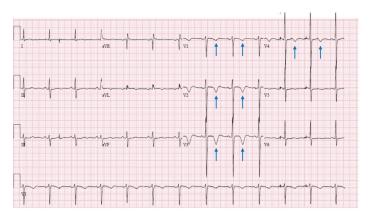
Initial echocardiogram with deep and symmetric T-wave inversions in leads V1-V4 (blue arrows), with no Q-waves, normal R-wave progression, and no ST-segment elevations, concerning for Wellens syndrome.
